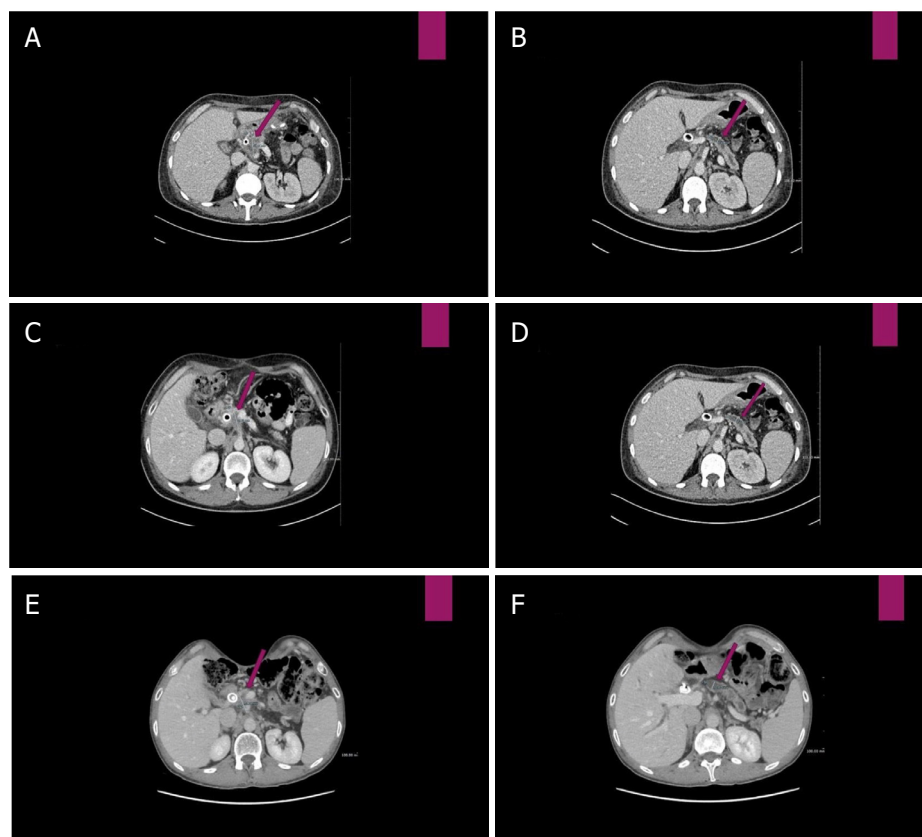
A: Computed tomography (CT) scan before Nab-paclitaxel-Gemcitabine therapy: hypodense lesion of 30 mm maximum transverse diameter, infiltrating the posterior lamina and presenting contact with the superior mesenteric artery; B: Wirsung duct dilatation of 8.42 mm; C: CT scan after Nab-paclitaxel-Gemcitabine therapy and consolidation radiotherapy: volumetric stability of the pancreatic lesion (29.76 mm); D: the Wirsung duct caliber (7.99 mm); E: 63 months from start therapy (after Nab-paclitaxel-Gemcitabine, radiotherapy and FOLFIRINOX salvage therapy) presence of slight reduction of the pancreatic lesion (25.38 mm maximum transverse diameter); and F: increase of the Wirsung caliber (10.67 mm) with atrophy of the pancreas body and tail
